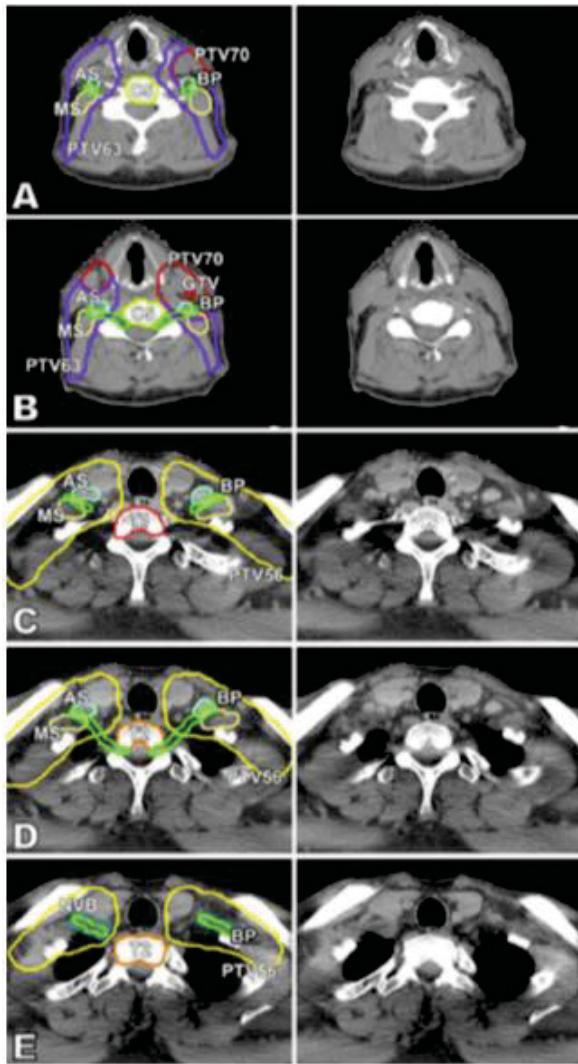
From Hall et al (2008): Major anatomic landmarks (Anterior and Middle Scalene muscles, and the neurovascular bundle) for identifying the brachial plexus on the axial images of a treatment planning computed tomography scan.
